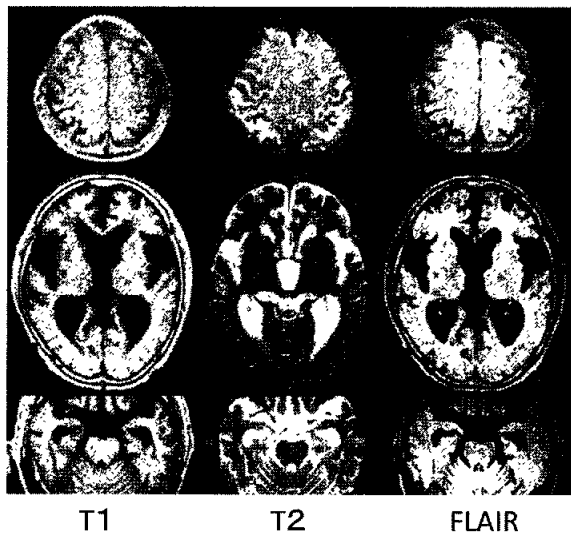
Axial views of magnetic resonance imaging (MRI) just before CSF shunting, T1-weighted MRI (*left*), T2-weighted MRI (*middle*), and fluid-attenuated inversion recovery (FLAIR) MRI (*right*). Ventricular dilatation (Evans ratio >3) with peri ventricular lucency (PVL) and a slack subdural space, and trapped CSF were observed in the Sylvian fissure. These findings were less diagnostic for iNPH, and rather they were viewed as brain atrophy or a mixed configuration of iNPH and brain atrophy
